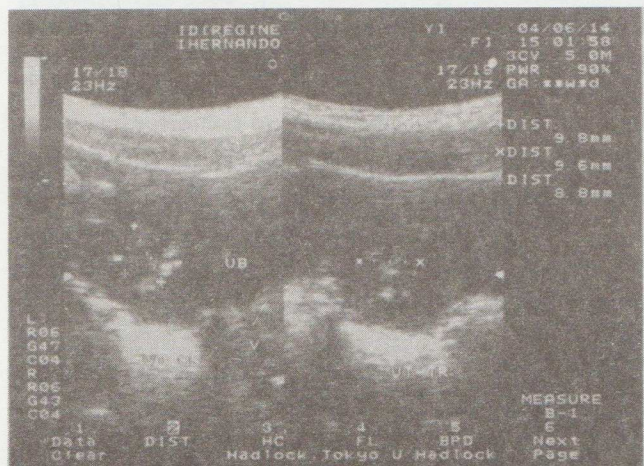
Transabdominal ultrasound anteroposterior and transverse views showing a fundal mass with echogenic areas.
